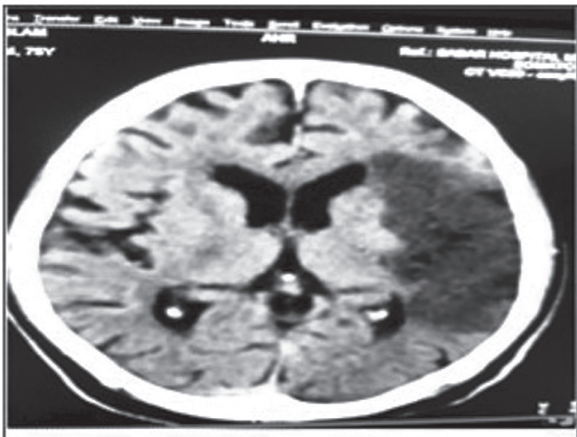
CT Scan of brain. Left MCA territory large acute infarct.
